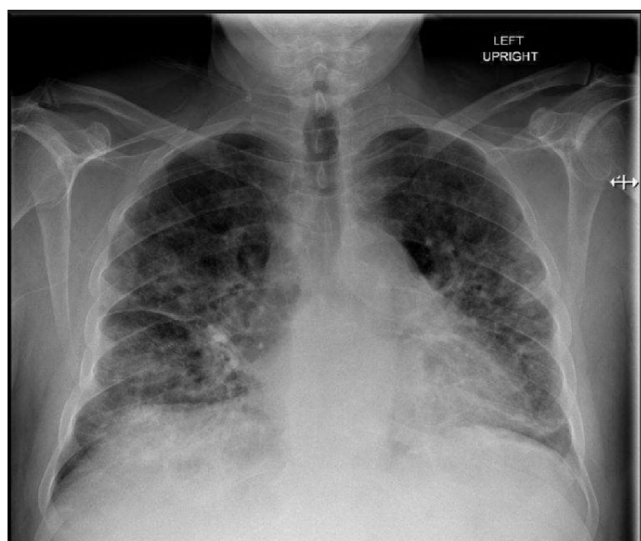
Chest radiograph demonstrating multifocal pneumonia.
